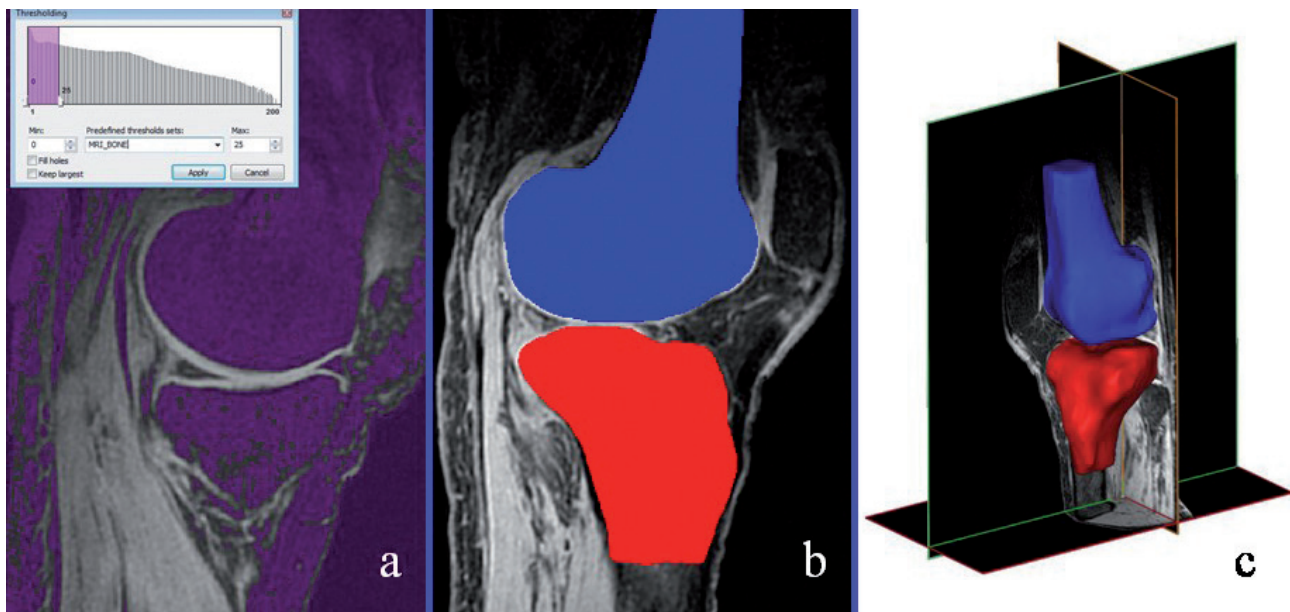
The MRI segmentation implied an automatic threshold-based marking of regions of interest on each sagittal T1-weighted high-resolution image of the knee (a), identifying two distinct areas for the femur and tibia (b). Repeating this process for all the 2D images and interpolating data, a 3D model was built (c).
